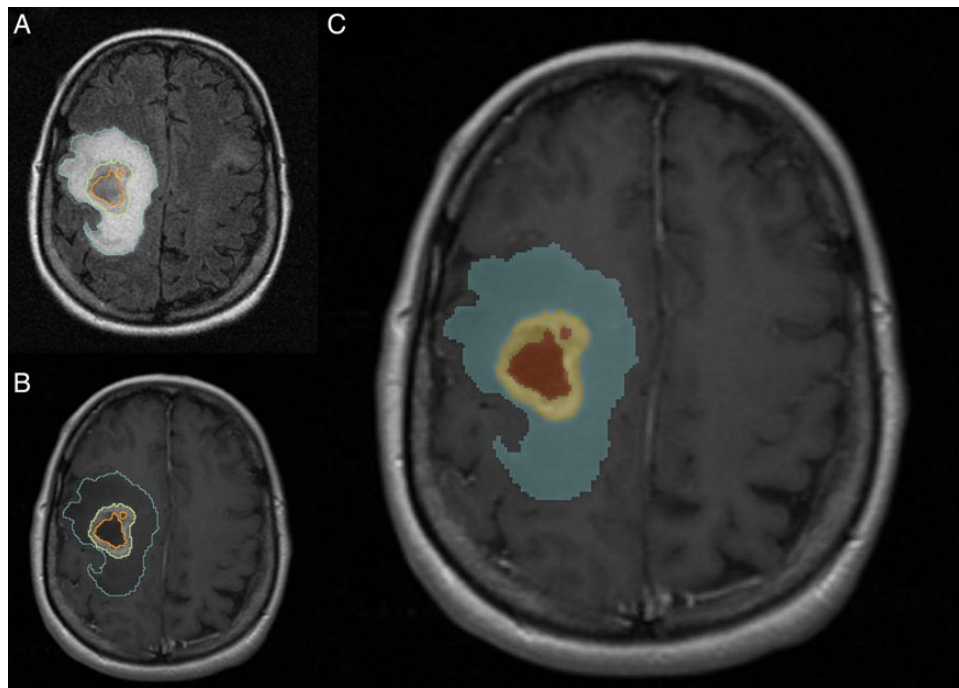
A 51-year-old female patient with right frontoparietal GBM. Representative case of tumor segmentation. (A) Axial FLAIR image shows segmentation of the FLAIR hyperintensity region defined as edema/tumor invasion (blue) (B) Axial postcontrast T1WI demonstrates segmentation of the enhancing tumor (yellow) and area of necrosis (orange). (C) Label map image demonstrating the segmented tumor.
